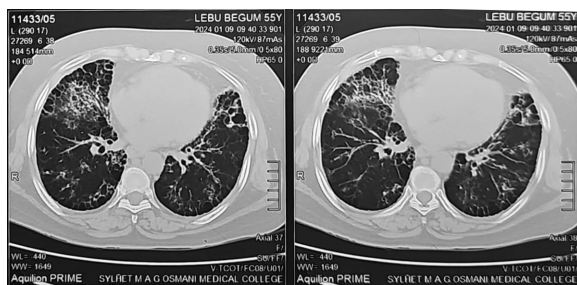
A CT scan of the chest lung window shows multiple air space opacities with intralobular and intralobular septal thickening and ground glass opacities in both lungs, which indicate interstitial syndrome (case no. 19).
